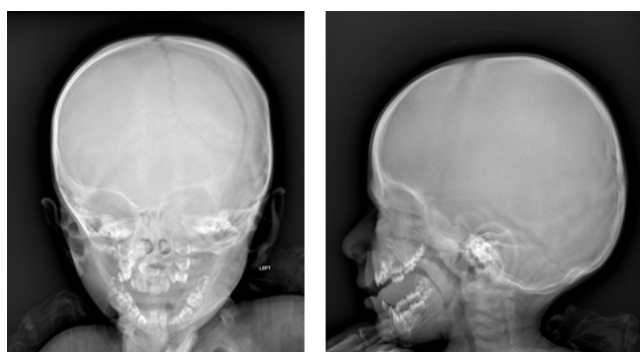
Skull X-ray showing a large skull diameter.
